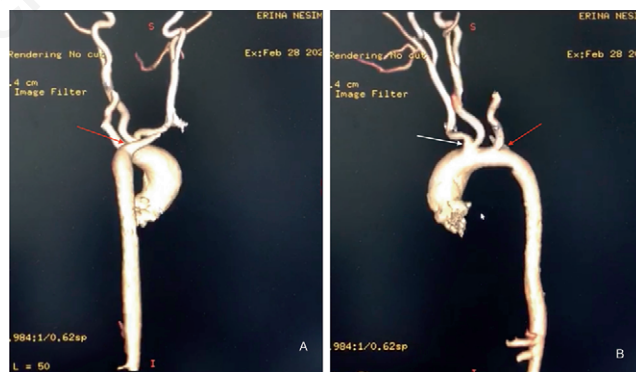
CT angiography A) lateroposterior view showing ARSA (red arrow), B) anterior view showing ARSA (red arrow), truncus bicaroticus (white arrow).
